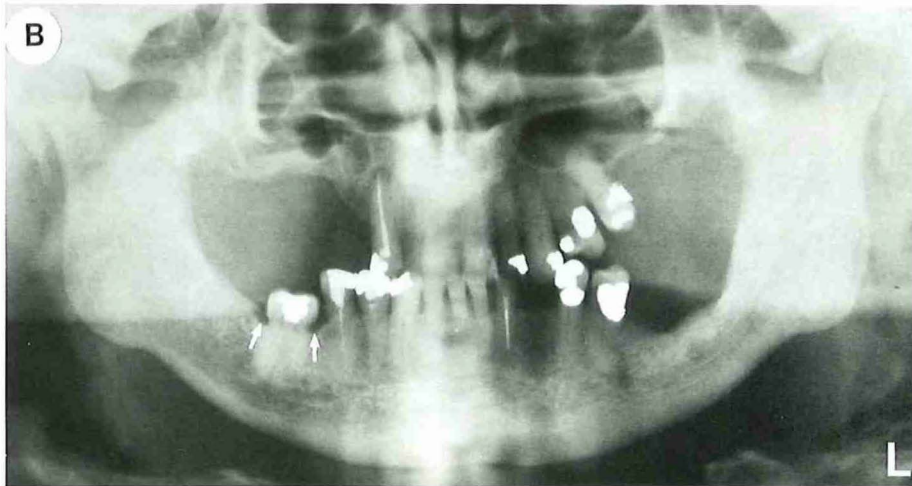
A Intraoral view of her 52-year-old father with secondary retention of the right mandibular first molar. B Orthopantomogram of the father. Note the decreased margin of the alveolar bone in the area of the affected first molar (arrow).
